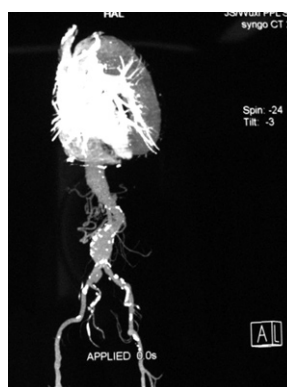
CT angiography of the aorta showed large ectasia from the ascending aorta to the right common iliac artery.
